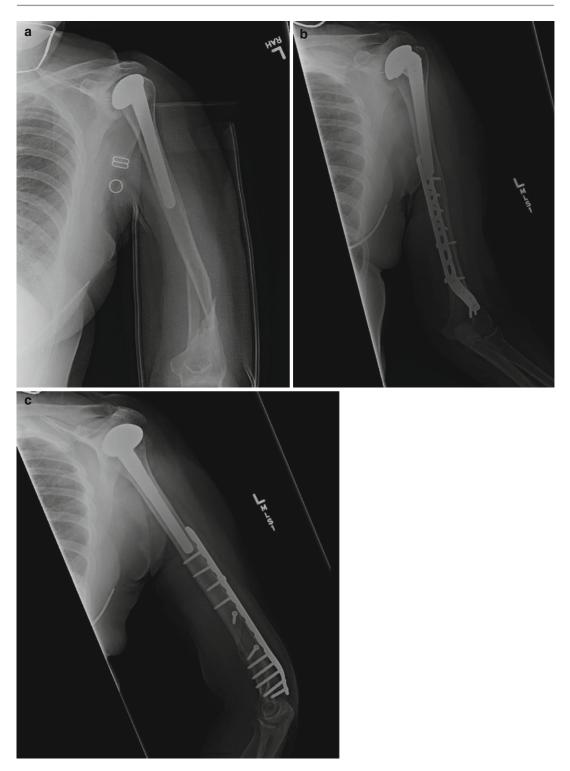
(a) Preoperative X-ray for a Type IV periprosthetic fracture. (b, c) Postoperative x-rays showing open reduction and internal fixation
